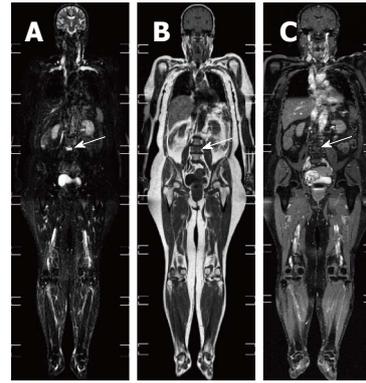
Whole-body magnetic resonance imaging of an osseous myeloma lesion. Whole-body magnetic resonance imaging: short-tau-inversion-recovery sequence (A), T1-weighted image (B) and T1-weighted image with fat suppression after contrast administration (C) showing an osseous lesion in L4 (arrows) representing an osseous myeloma manifestation.
